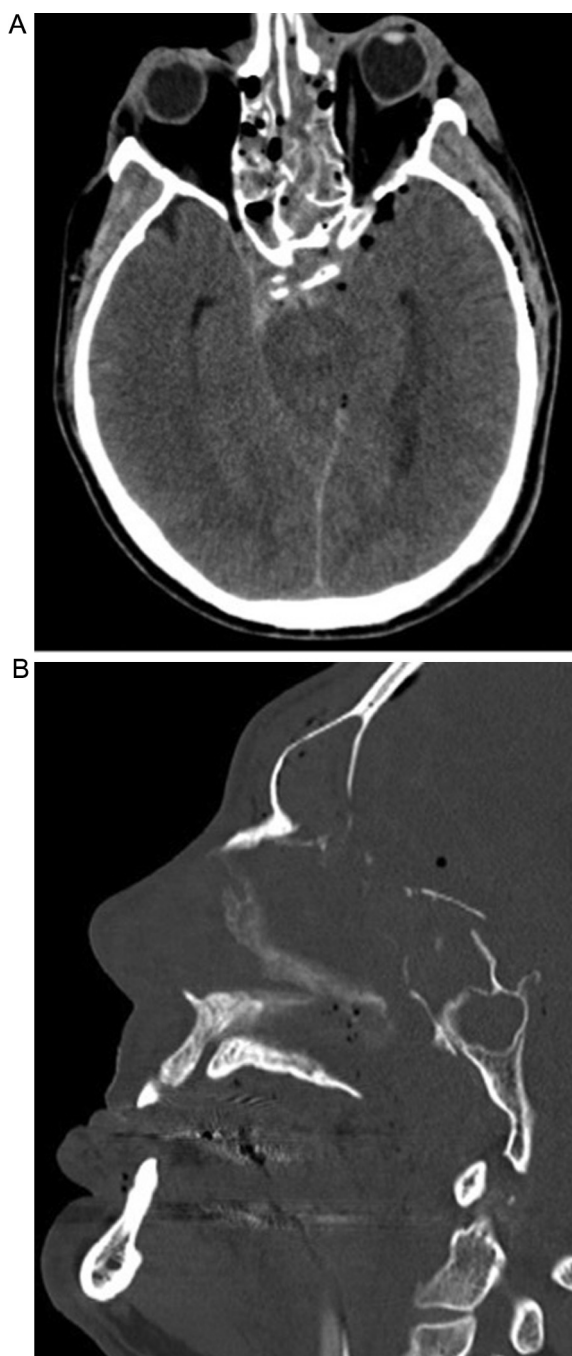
(A) Axial non-contrast head CT demonstrating traumatic pneumocephalus and intracranial hemorrhage. (B) Sagittal reconstruction of non-contrast thin-cut head CT demonstrating fractures of the cribriform plate, and frontal and sphenoid sinuses.
